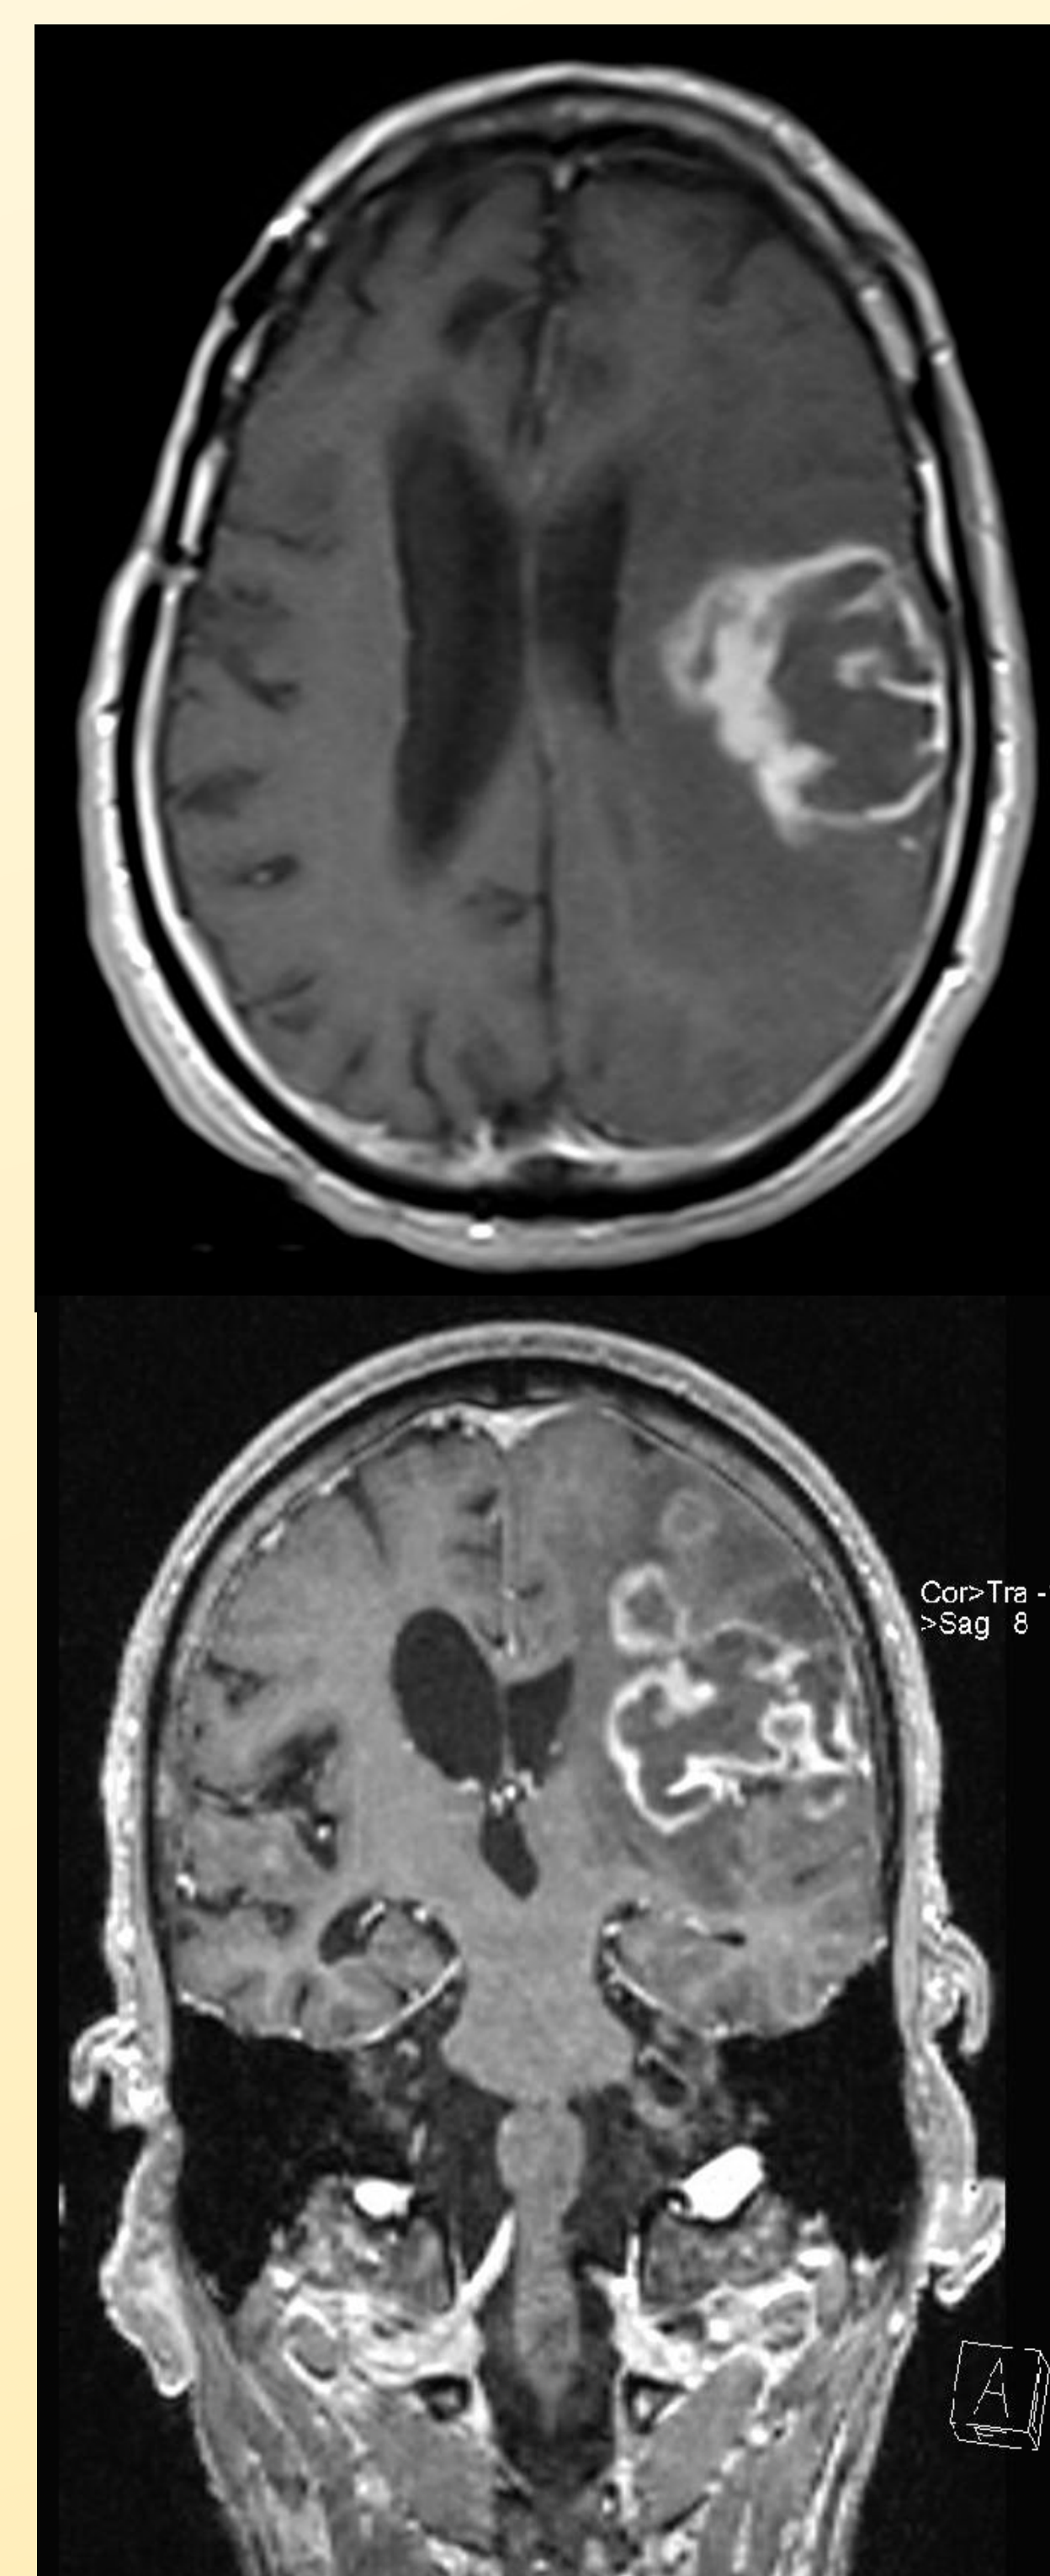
MRI from recent admission with recurrence of cerebral toxoplasmosis revealing multiple ring enhancing lesions associated with perilesional oedema.
